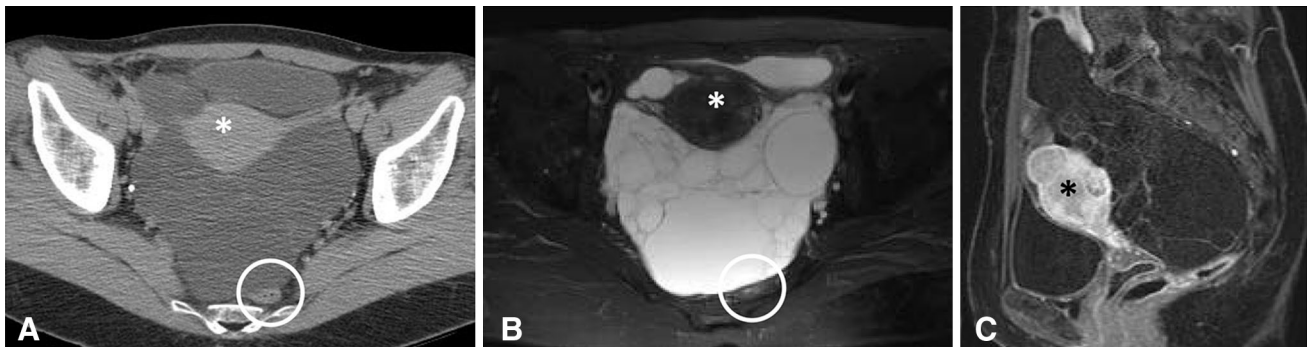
Surgically proven multicystic benign mesothelioma. A Axial CECT shows a large cystic mass which compresses the rectum (circled) posteriorly. B Axial T2-weighted image demonstrates the multicystic nature of this mass and better
